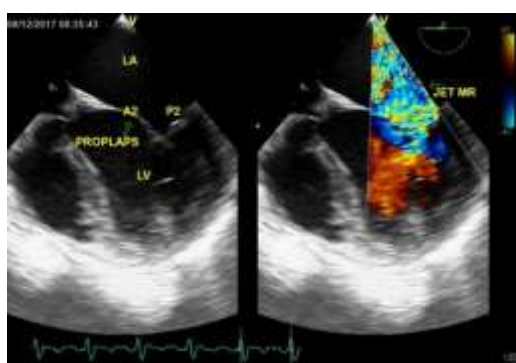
Transoesophageal echocardiography (TEE) showed severe mitral regurgitation (MR) due to A2 segment prolapse
